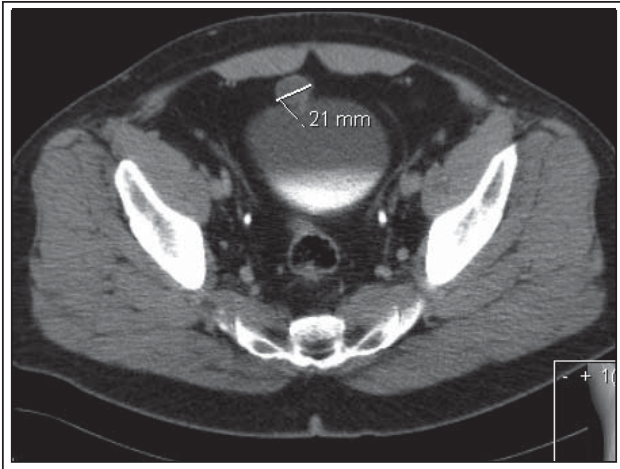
Urinary bladder tumor involving the dome with extravesical extension (CT scan with contrast).
